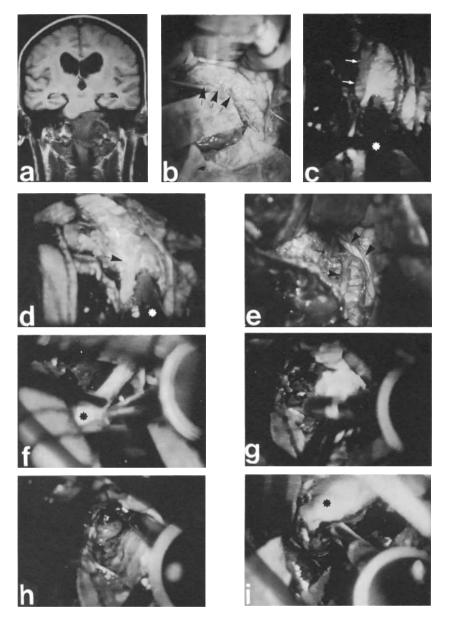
Surgical ultrasonic aspiration of brain tumors (selected examples; intraoperative video images). a-e Removal of a large meningioma of the foramen magnum: a NMR image of the right-sided meningioma located in the foramen magnum. b Intraoperative view of the tumor mimicking the brain stem and the blood vessels. c,d Skeletonizing the vertebral artery (arrow), PICA, and brain stem $\overline{(double\ arrow)}$ after partial tumor resection. f Resection of a large suprasellar pituitary adenoma (right subfrontal route). Chiasm (*). g Evacuation of a metastatic brain tumor. h Intracapsular removal of an acoustic neurinoma. i Layer-by-layer dissection of a medulloblastoma. Floor of the fourth ventricle (*)
